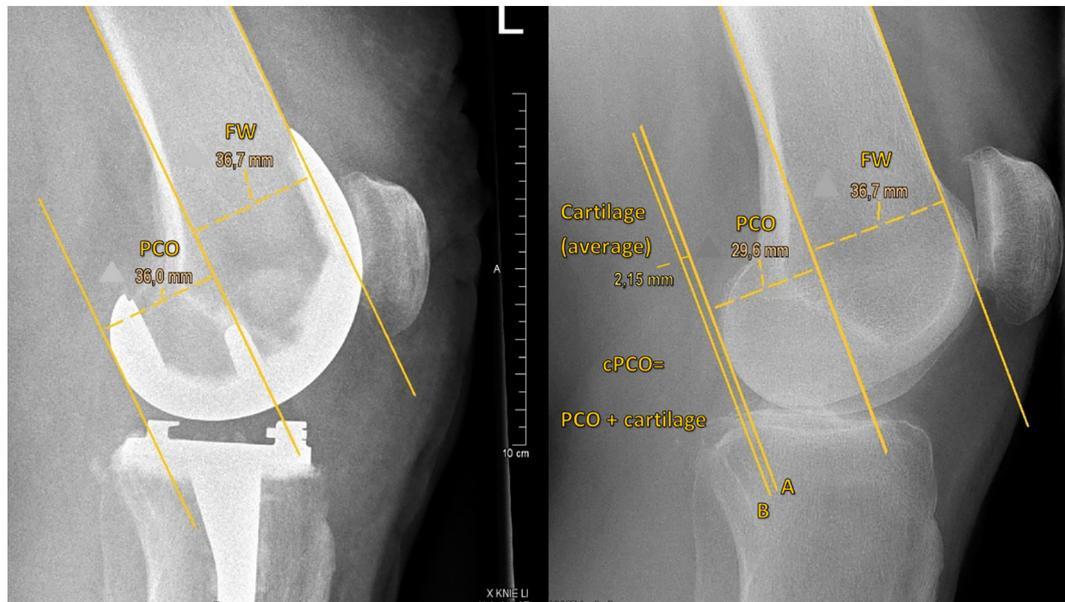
Radiological measurements for posterior condylar offset changes. The right figure shows a preoperative true lateral radiograph with complete overlap of the medial and lateral posterior condyl. The left figure shows a postoperative true lateral radiograph. Abbreviations: PCO: posterior condylar offset line distance; FW: Femoral width; cPCO: corrected posterior condylar offset distance; A: joint line bony edge femur; B: actual joint position.
